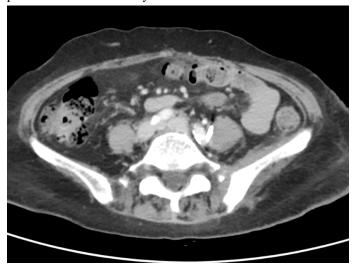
Contrast enhanced CT scan of the pelvis shows almost complete resolution of the enhancing soft tissue in the left psoas, iliacus, and gluteal musculature.
